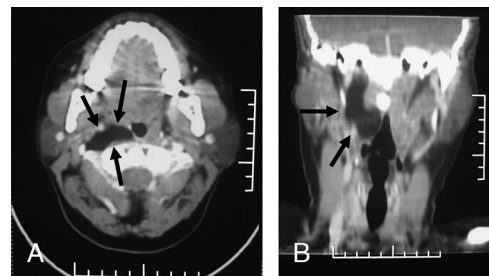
The lipoma on axial (A) and coronal (B) reformatted CT scans in 2009 (arrows).
